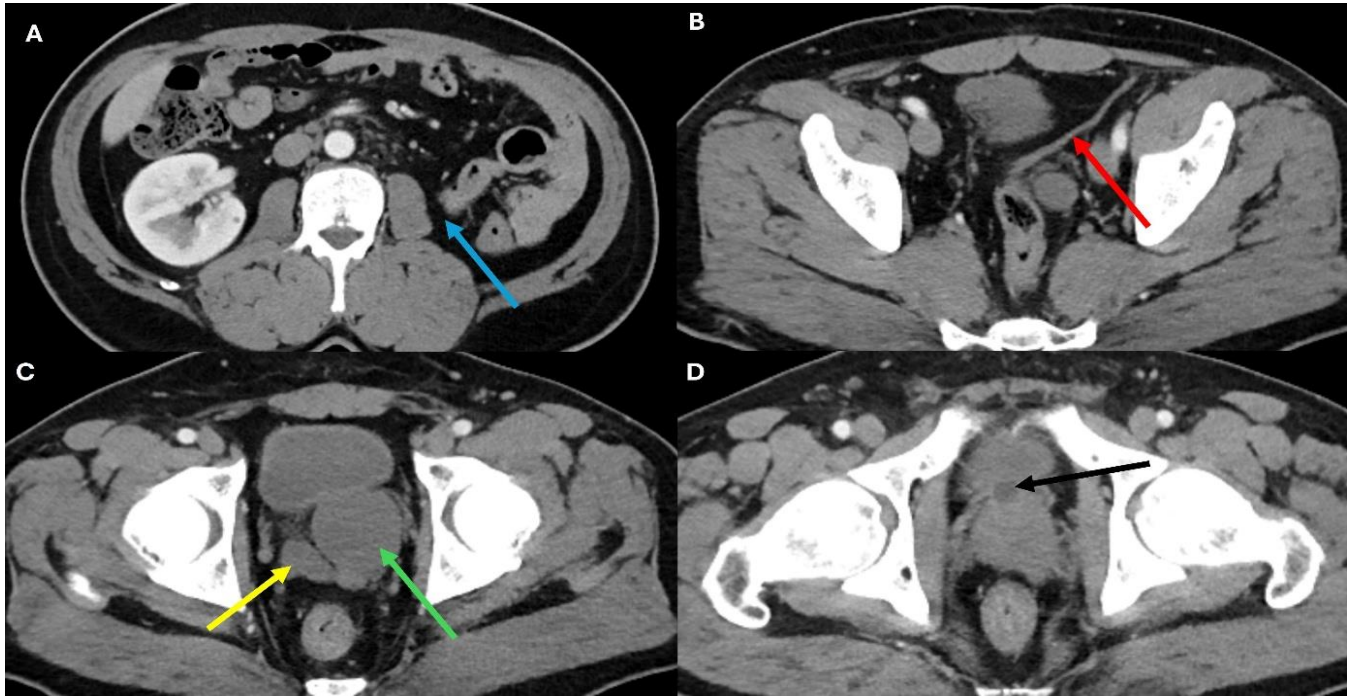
Contrast-enhanced axial abdominal CT images of the patient. In the first image (A), the left kidney is not visualized in its normal anatomical location (blue arrow). In the second image (B), dilation of the left vas deferens is observed (red arrow). In the third image (C), the right seminal vesicle appears normal (yellow arrow), whereas a cystic lesion originating from the left seminal vesicle is noted (green arrow). In the final image (D), a well-defined cystic lesion is seen anterior to the prostate gland (black arrow).
